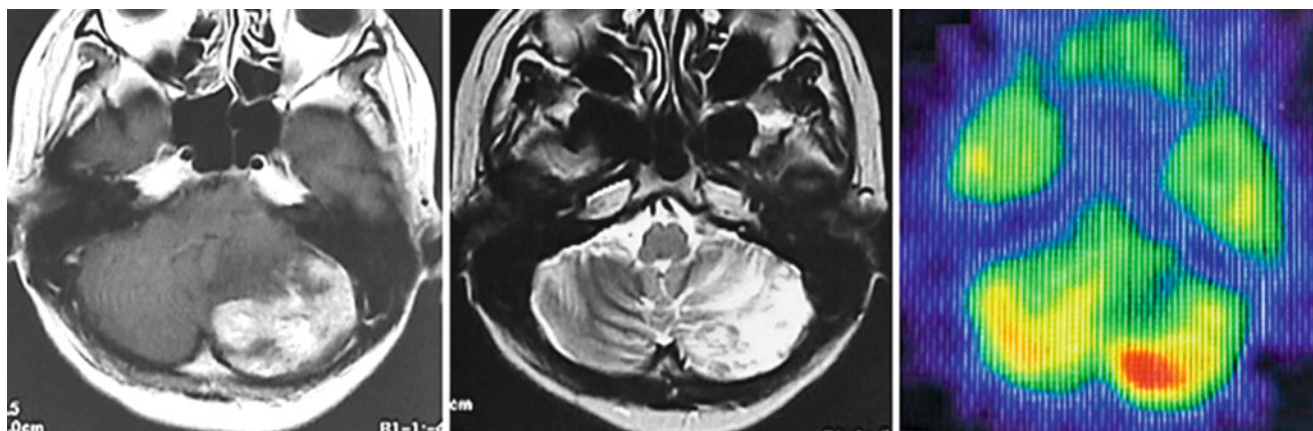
T1-weighted (*left*) and T2-weighted (*center*) MRI and ^{18}F -fluorodeoxyglucose–positron emission tomography (FDG-PET) (*right*) of a metastatic adenocarcinoma in the left cerebellar hemisphere progressing after GKS (*Source*: Chernov et al. [11])
